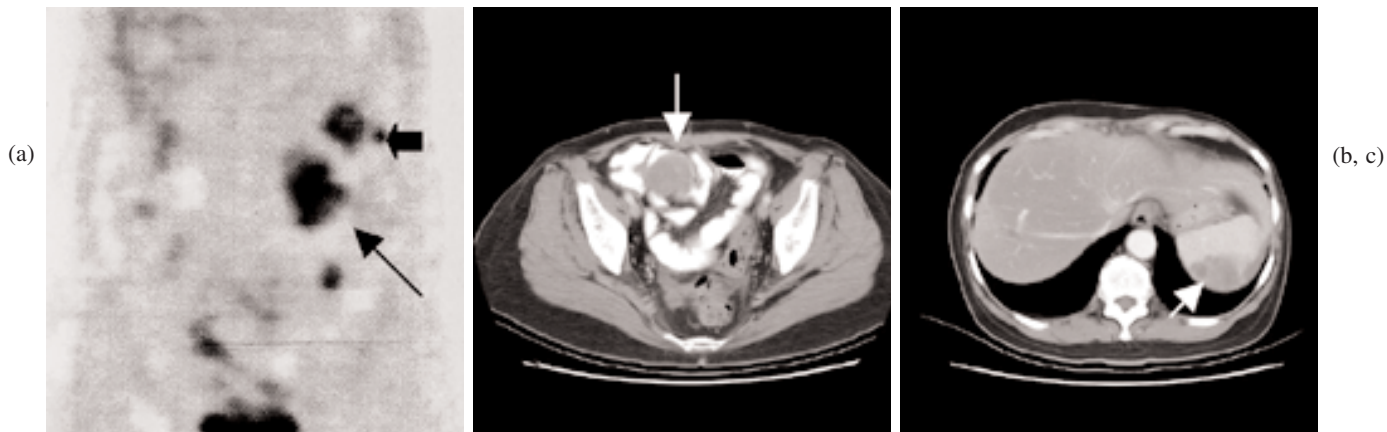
Patient 1 (a case of MMMT): (a) whole body FDG-PET detected peritoneal carcinomatosis and spleen metastasis (black arrows, coronal view) (b, c) abdominal CT showed carcinomatosis and spleen tumor (white arrows, transaxial view).
